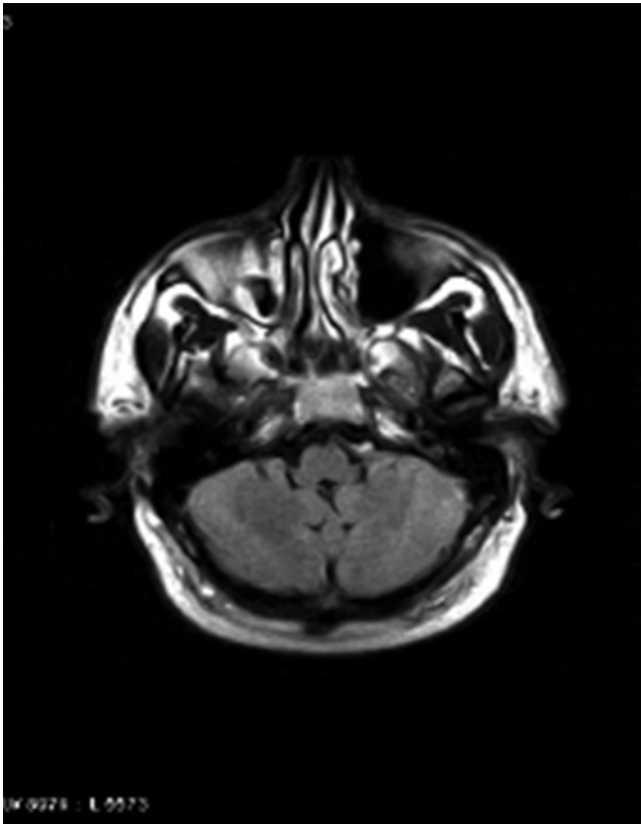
Magnetic resonance imaging in 2006 before shunting
